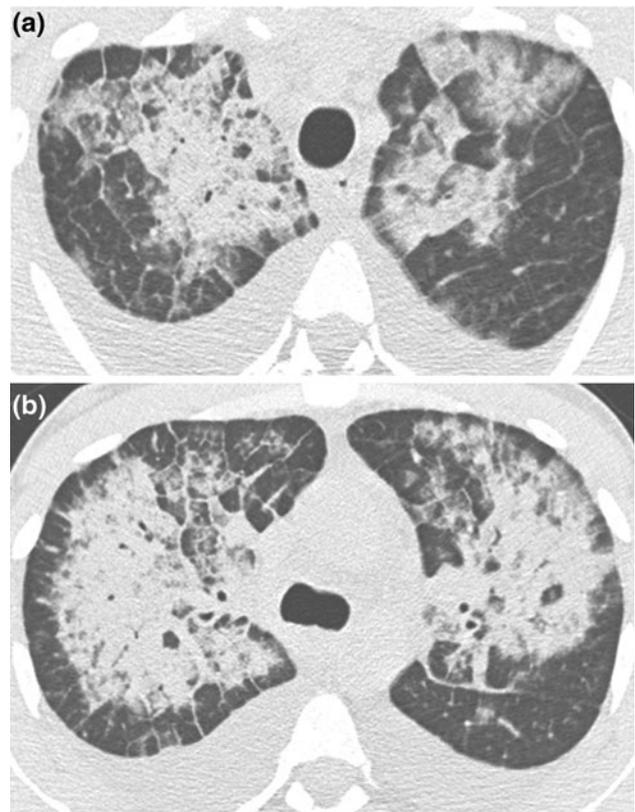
Acute pulmonary edema in a 29-year-old man presenting with cough, black sputum, and hemoptysis after 9 months of cocaine use. Chest HRCT images (a, b) show ground-glass opacities associated with smooth interlobular septal thickening (*crazy-paving pattern*) and bilateral pleural effusion. Note in b the perihilar distribution of the lesions, with peripheral regions spared
